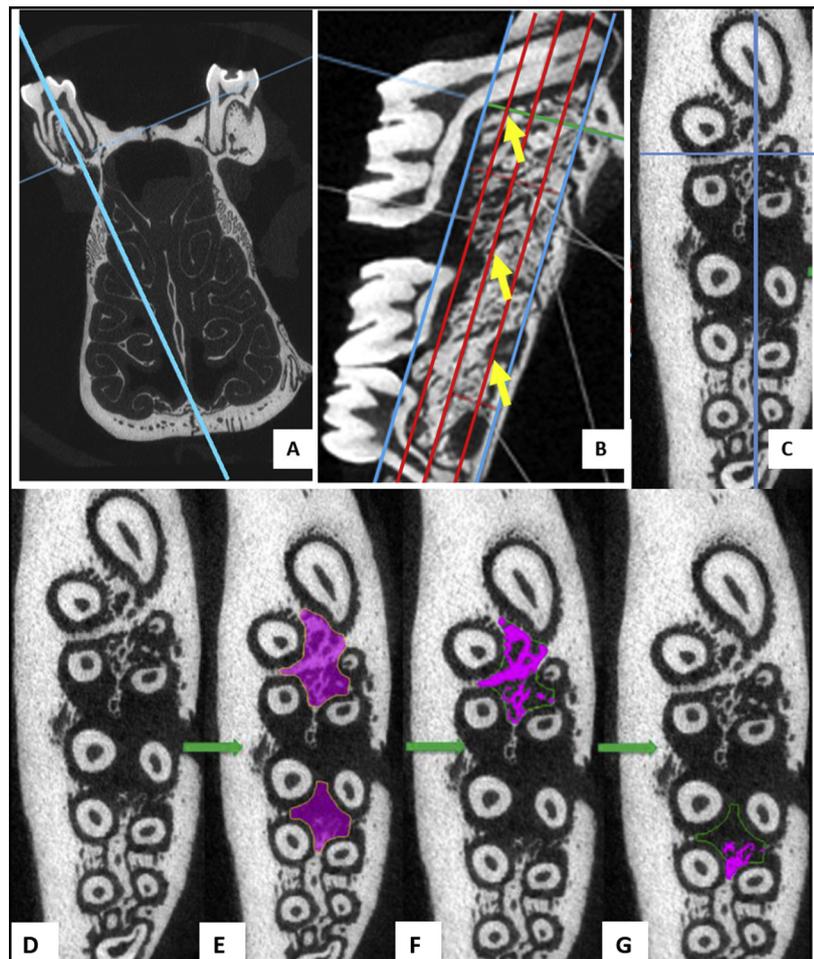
Orientation of μ CT image and measurement of BV/TV. A, Alignment of sagittal axis with the long axis of the first molar. B, Alignment of transverse axis parallel to the alveolar ridge, and a line drawn parallel to the transverse axis at the apex of the mesial root. The perpendicular line connecting the transverse axis and the parallel line at the apex of the mesial root were trisected to represent the one-quarter root, the mid-root, and the three-quarter root levels. C, The transverse axis in the sagittal plane was then moved toward the apex of the mesial root, and the corresponding images in the axial plane at the one-quarter root, the mid-root, and the three-quarter root levels were obtained as TIFF images. D-G, Defining region of interest and measurement of BV/TV in the interradicular region of first molar and second molars.
